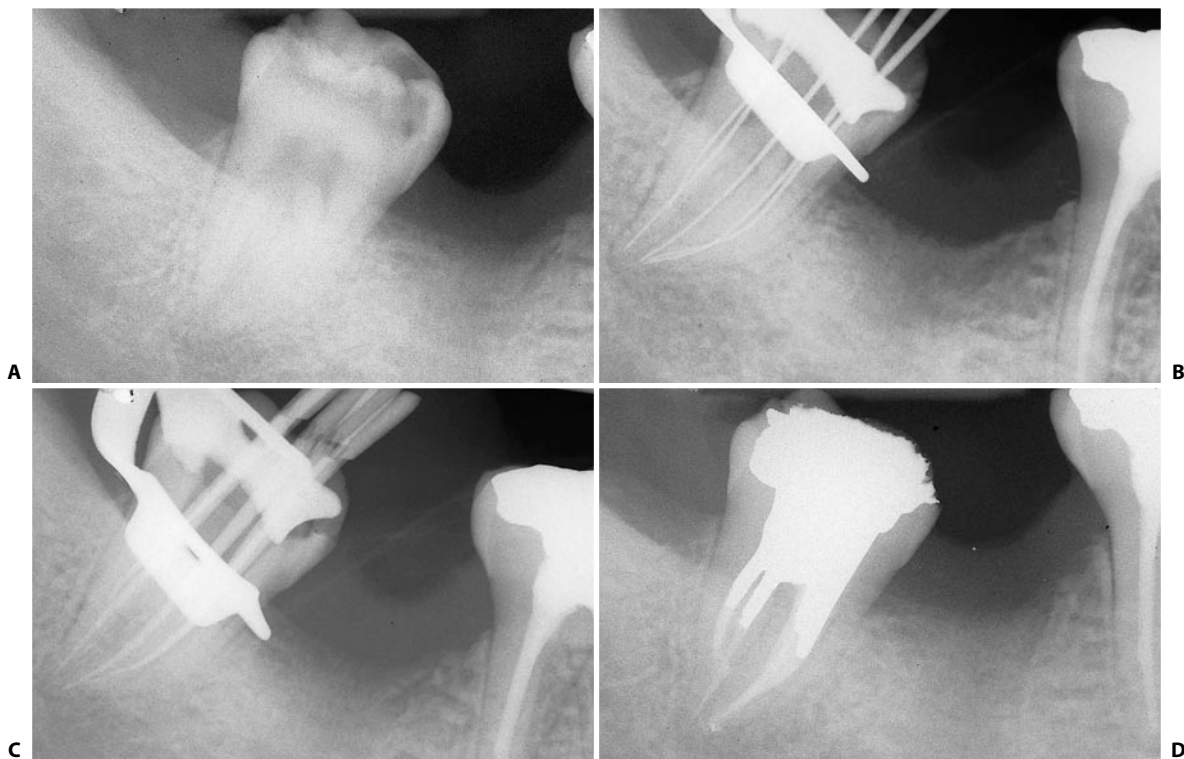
A lower right third molar with five canals. A. Preoperative radiograph. B. Intraoperative radiograph: two canals are present in the distal and three in the mesial root. C. Cone fit. D. Postoperative radiograph.
